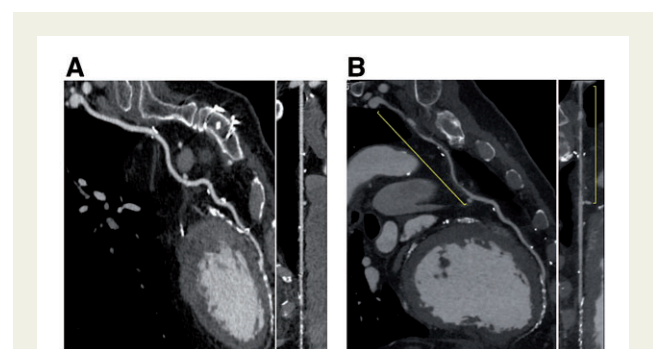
(A) Computed tomographic angiography assessed at 7 years after coronary artery bypass grafting, showing good graft patency without any abnormal findings. (B) Computed tomographic angiography assessed at 11 years after coronary artery bypass grafting, showing diffuse stenosis in the proximal half of the left internal thoracic artery (yellow line).
